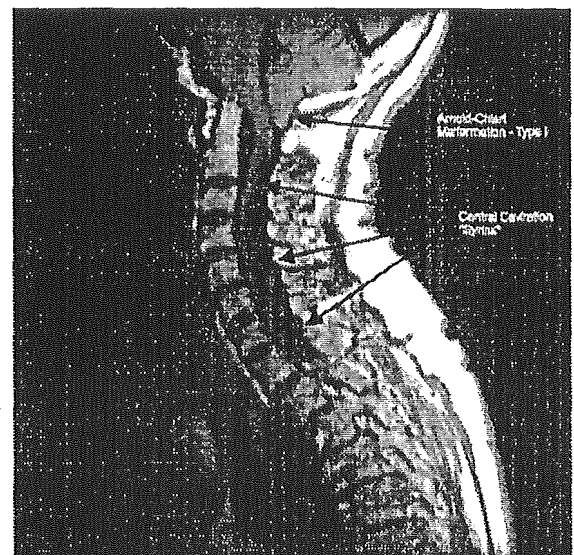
T1 weighted magnetic resonance imaging of the cervical and upper thoracic spine. The cerebellar tonsils descend below the foramen magnum—indicative of the Arnold-Chiari I malformation. A central cavitation is evident from the hypointense signal within the central portion of the cervical spinal cord.
